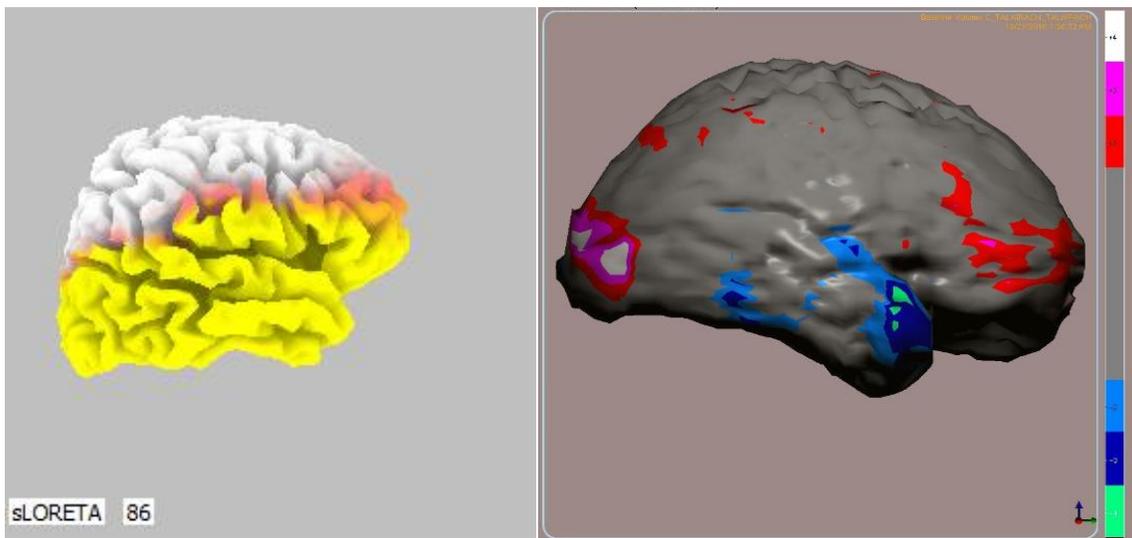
The 34.65Hz source localization compared to a typical right hemispheric NRF ME/CFS SPECT map.
